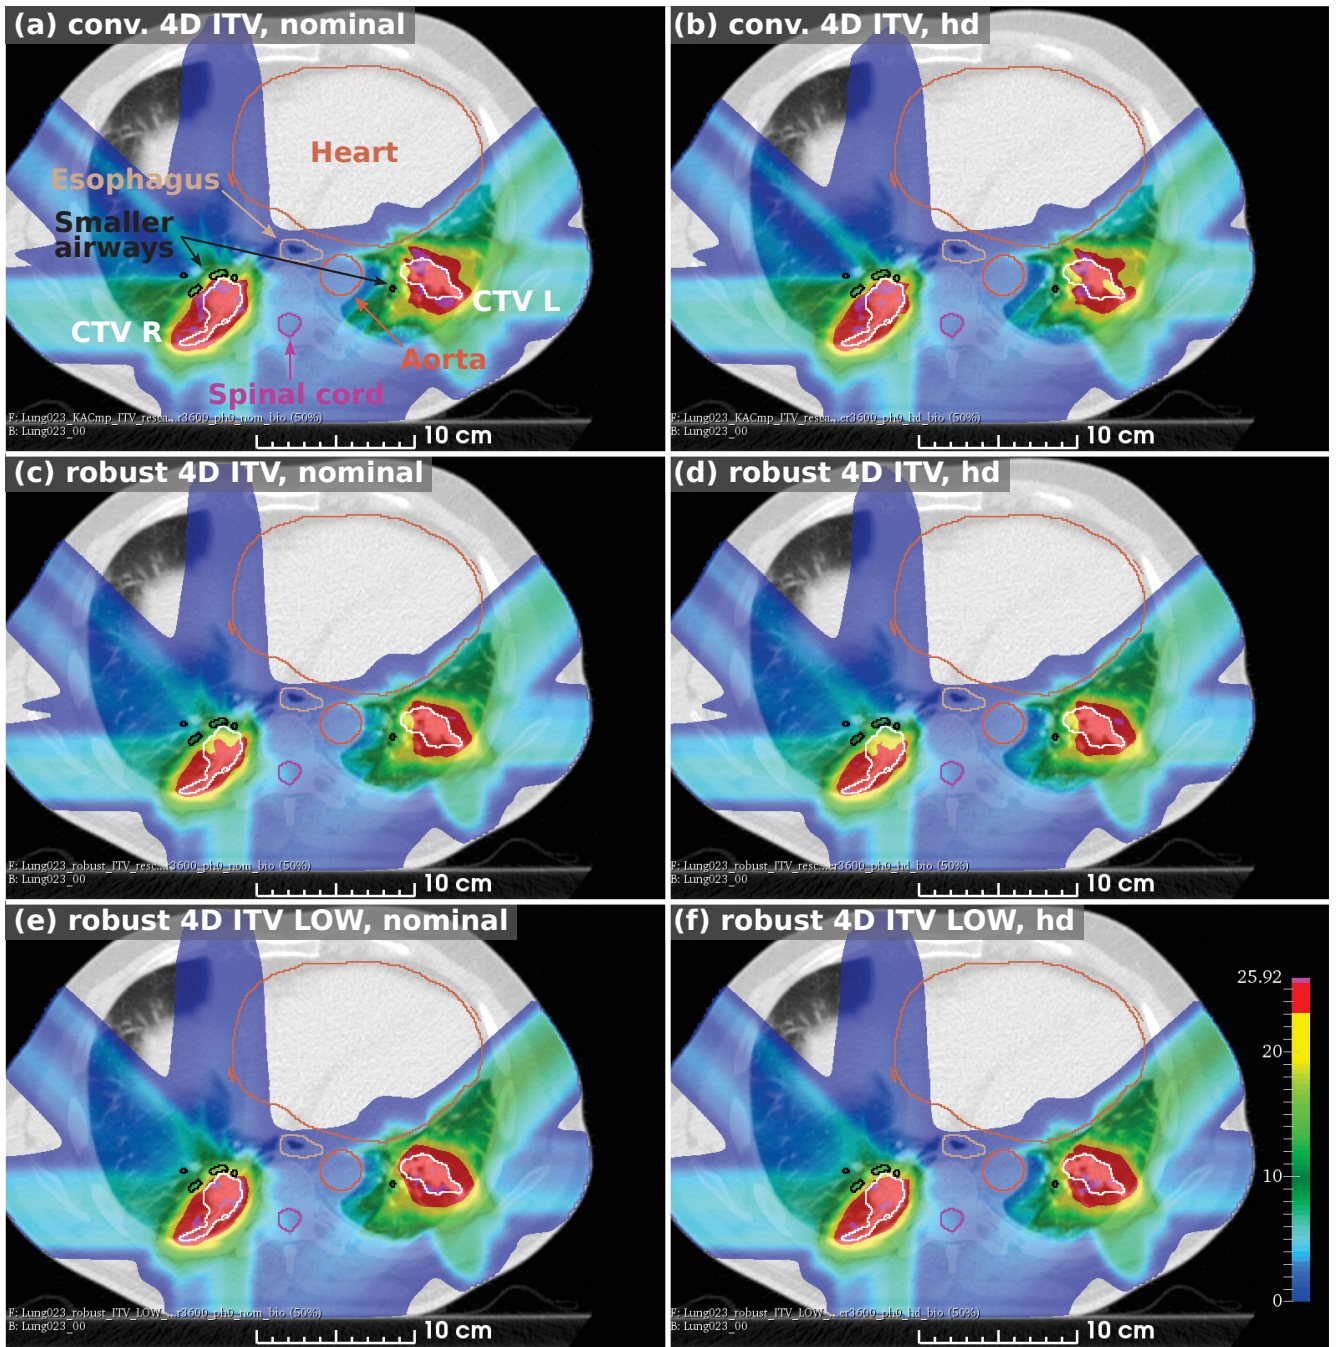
Axial view of 4D dose distribution overlaid on CT reference phase for patient 23 in the nominal (nom) and high density (hd) scenario with Lujan period of 3.6 s and starting phase of 0° . Panel (a) and (b) show the dose distributions resulting from the conventional optimized plan with right and left CTVs (white) as well as the smaller airways (black) and heart (brown) as critical structures. Panels (c) and (d) shows the dose distributions from the robustly optimized treatment plan and panels (e) and (f) show the robust plan with low OAR weights (LOW). Dose is shown in Gy(RBE).
